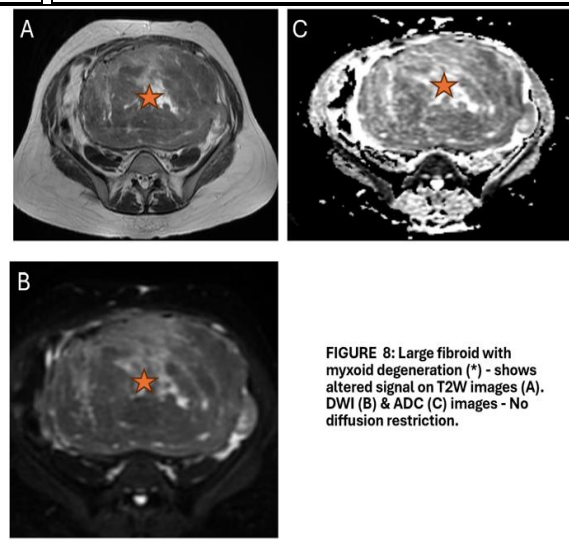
Large fibroid with myxoid degeneration (*) - shows altered signal on T2W images (A). DWI (B) & ADC (C) images - No diffusion restriction.
